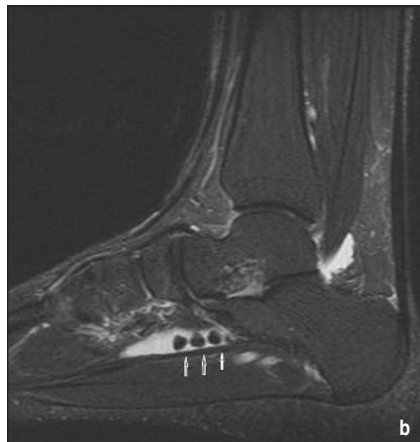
Sagittal T1- weighted and (b) sagittal T2 - weighted images fat suppression and (c) axial T2- weighted image with fat suppression MRI of the ankle demonstrates low signal intensity focal areas (arrow) within the flexor hallucis longus tendon sheath. The focal area is secondary to calcification.
